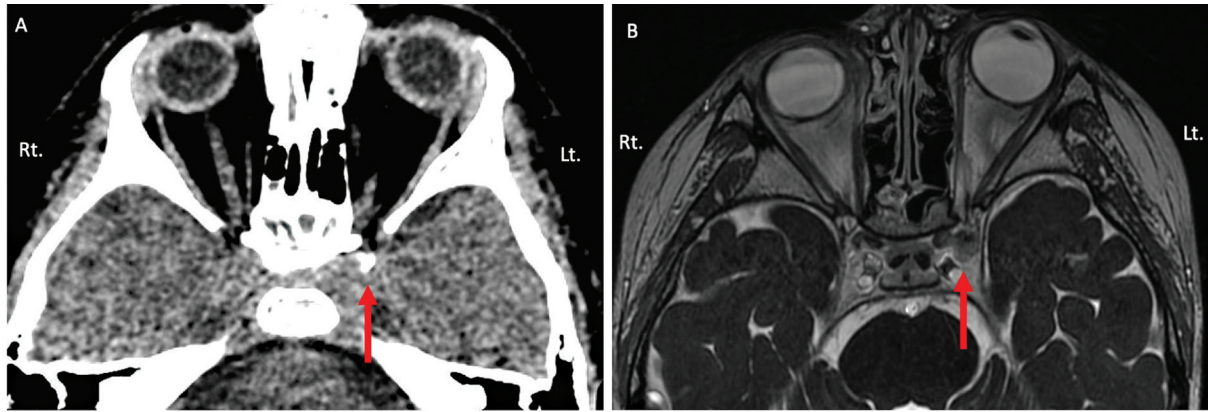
Head computed tomography (CT) and magnetic resonance imaging (MRI) of the patient. (A) CT reveals calcified lesion near the left superior orbital fissure (red allow). (B) Contrast-enhanced fast imaging employing steady-state acquisition (FIESTA) shows a nodular lesion in the cavernous sinus (red allow).
